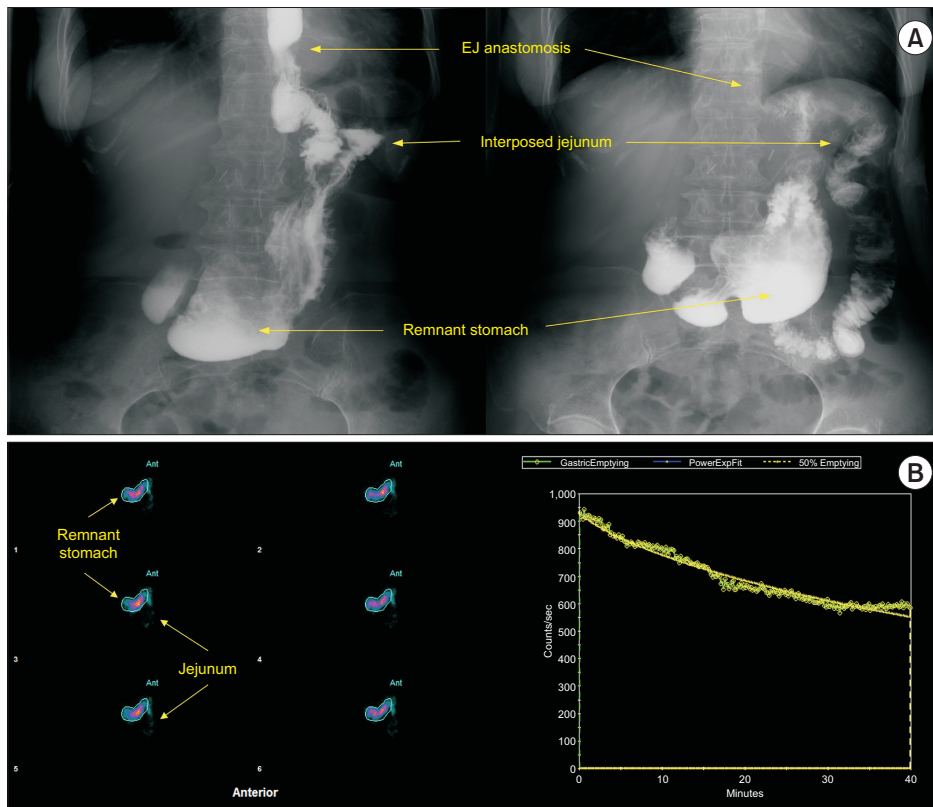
Evaluation of the food passage after surgery (findings from case 5 in Table 2). (A) Liquid passage assessed by the upper gastrointestinal contrast study. (B) Solid passage assessed by gastric emptying radionuclide scintigraphy. The regions of interest corresponding to the remnant distal stomach were outlined in the frame images. EJ, esophagojejunal.
